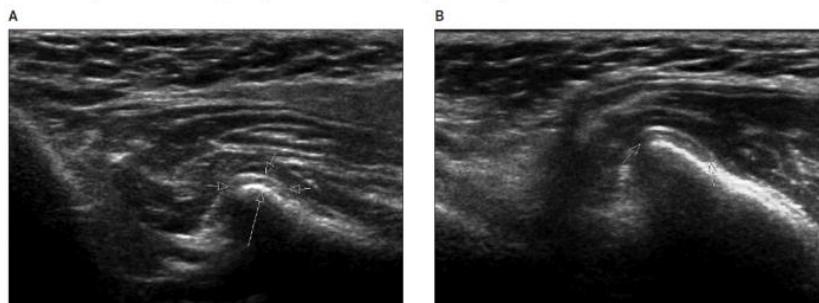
(Image Courtesy: The American Institute of Ultrasound in Medicine).
